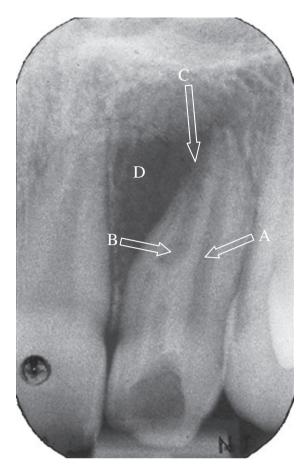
An intra-oral radiograph of a maxillary lateral incisor with Oehlers' Type IIIA. Note the the pulp canal (A) with an adjacent invagination (B) opening into the periodontal ligament (C) creating an apical radiolucency (D).
